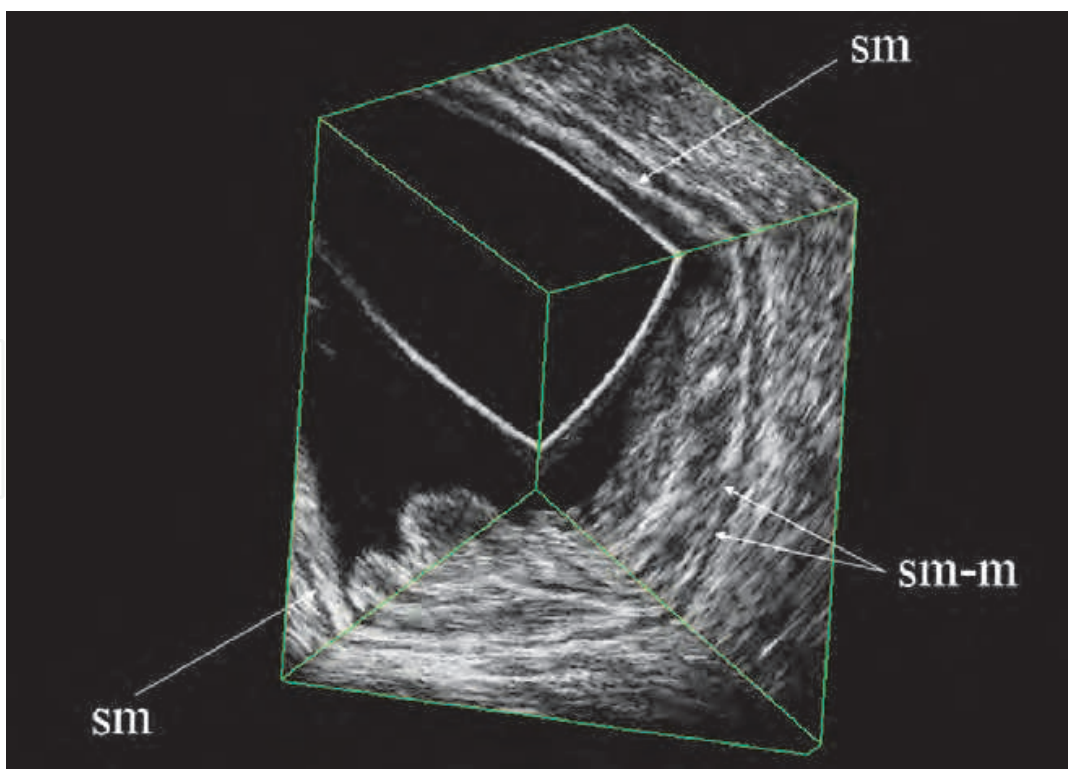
uT1-massive cancer are characterized at ultrasonography by a broadening of the first hypoechoic layer and a massive irregularity or a small focal disruption of the hyperechoic submucosal interface. The fourth hypoechoic muscular layer appears intact
